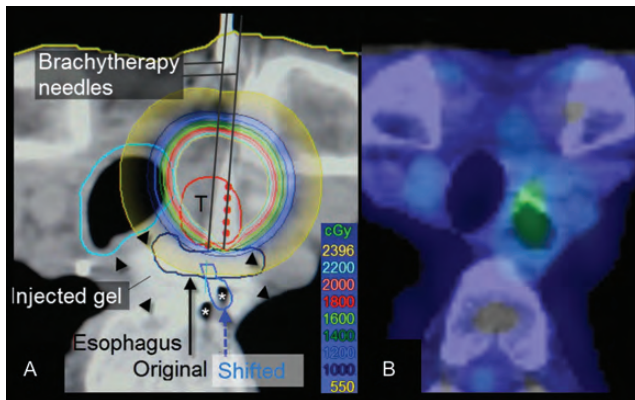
(A) Dose distribution in boost brachytherapy. Both the shifted and approximate original positions of the esophagus are contoured. T, gross tumor volume; asterisks, air space in the shifted esophagus (right) and injected air (left); arrowheads, extent of injected gel. (B) PET-CT image obtained 3 months after the boost brachytherapy shows disappearance of the tumor mass and no uptake.
